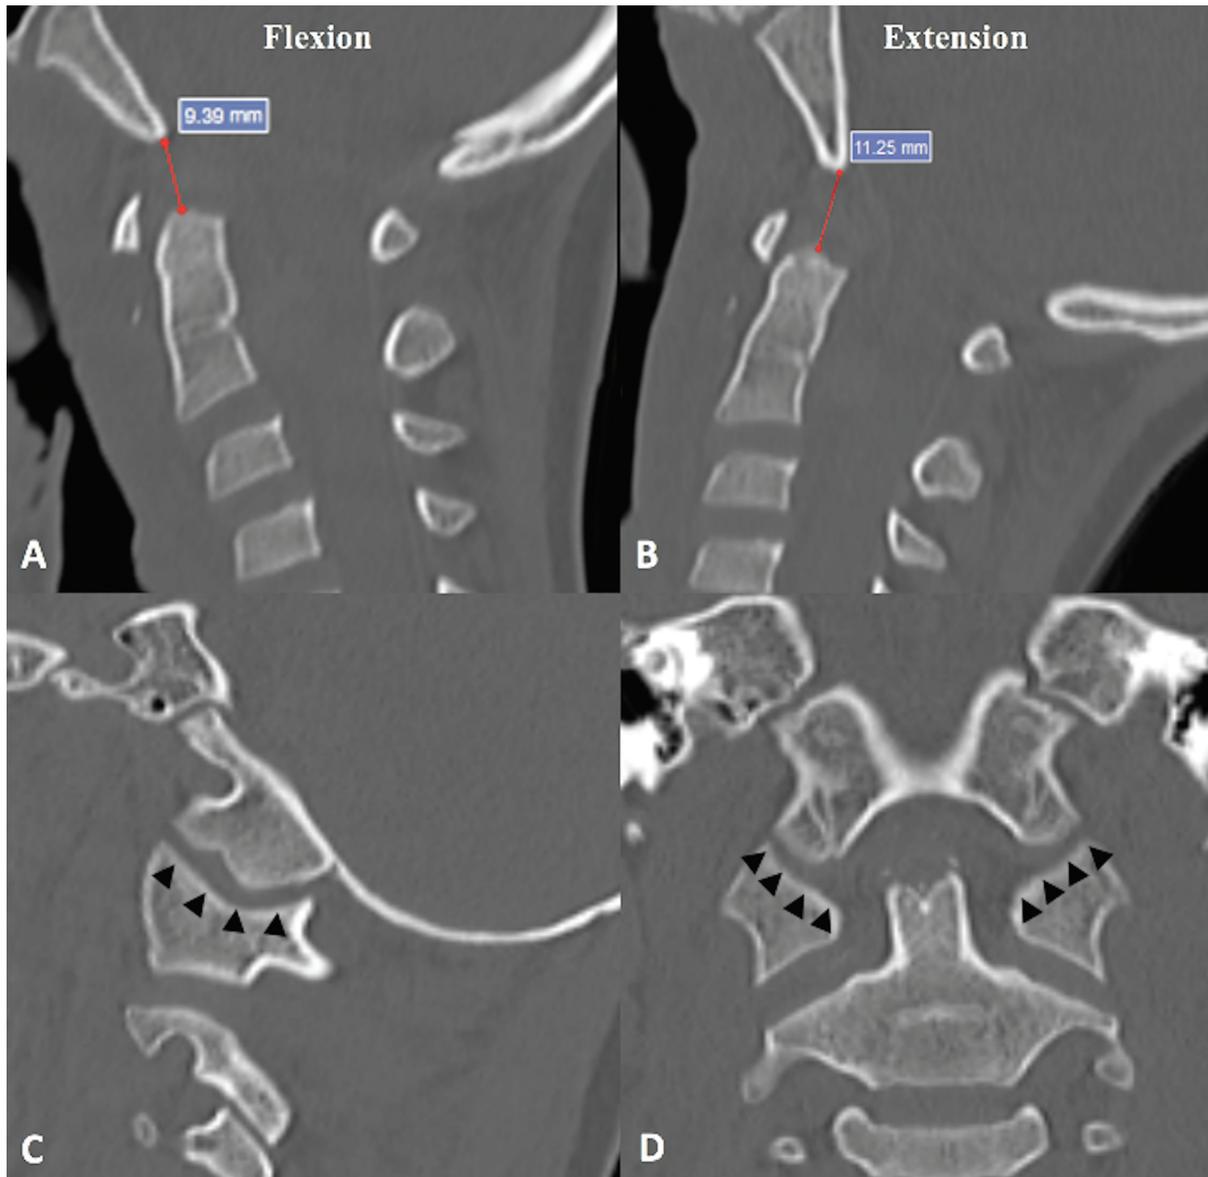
(A and B) Dynamic computed tomography (CT) scan showing the Wholey’s dens-basion interval. Note an increasing dens-basion interval on extension, in this case. (C and D) Conventional CT scan with placement of the measurement points (arrowheads) on the coronal (A) and sagittal (B) planes for calculation of the occipital condyle–C1 interval (CCI) in this case. A value of 4.05 mm was obtained (normal is < 4 mm).
